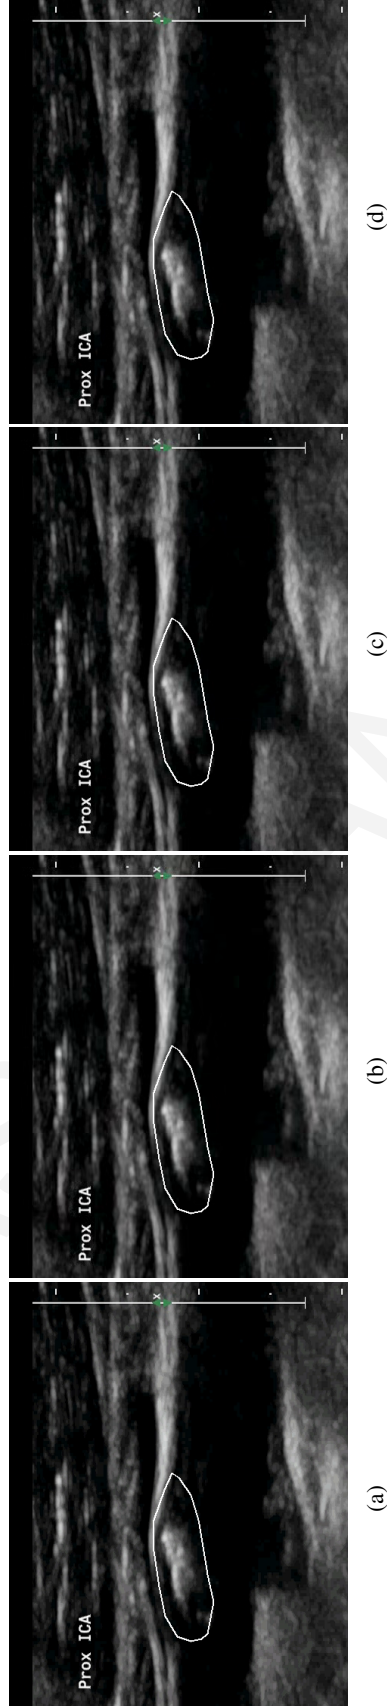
Ultrasound video image examples of *maximum video quality mode* described in Section 5.5.4.1. Atherosclerotic plaque segmentation is outlined by white lines [8], [81]. Video Resolution: 560x448, Frame Rate:40 fps. (a) Original (uncompressed) video image, (b) SSIM: 0.921, Bitrate: 290 kbps (constraint: ≤ 300 kbps), FPS: 48.29 (constraint: real-time encoding, i.e., ≥ 40 fps), QP: 31, Encoding Structure: B4, (c) SSIM: 0.949, Bitrate: 884 kbps (constraint: ≤ 1000 kbps), FPS: 46.63 (constraint: ≥ 40 fps), QP: 26, Encoding Structure: B2, (d) SSIM: 0.961, Bitrate: 1873 kbps (slight violation of constraint: ≤ 1800 kbps), FPS: 43.98 (constraint: ≥ 40 fps), QP: 23, Encoding Structure: B2.
